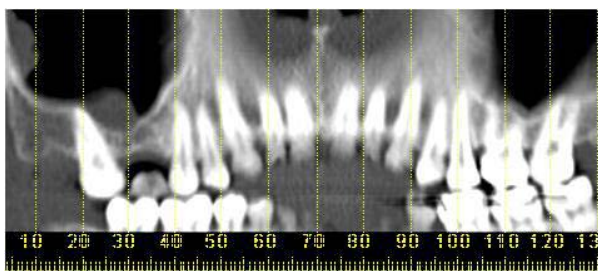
Panoramic projection in the CT of surgical zone.
